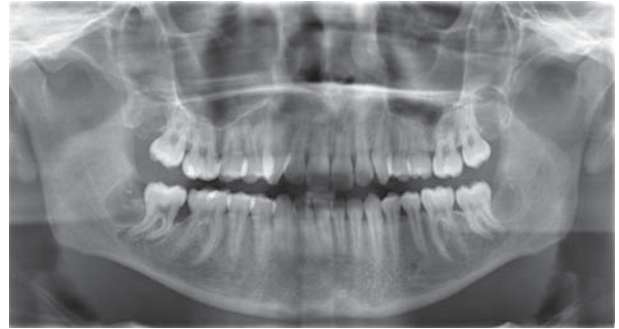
X-ray control after extraction of four impacted wisdom teeth and autotransplantation of the impacted lower right second molar.
